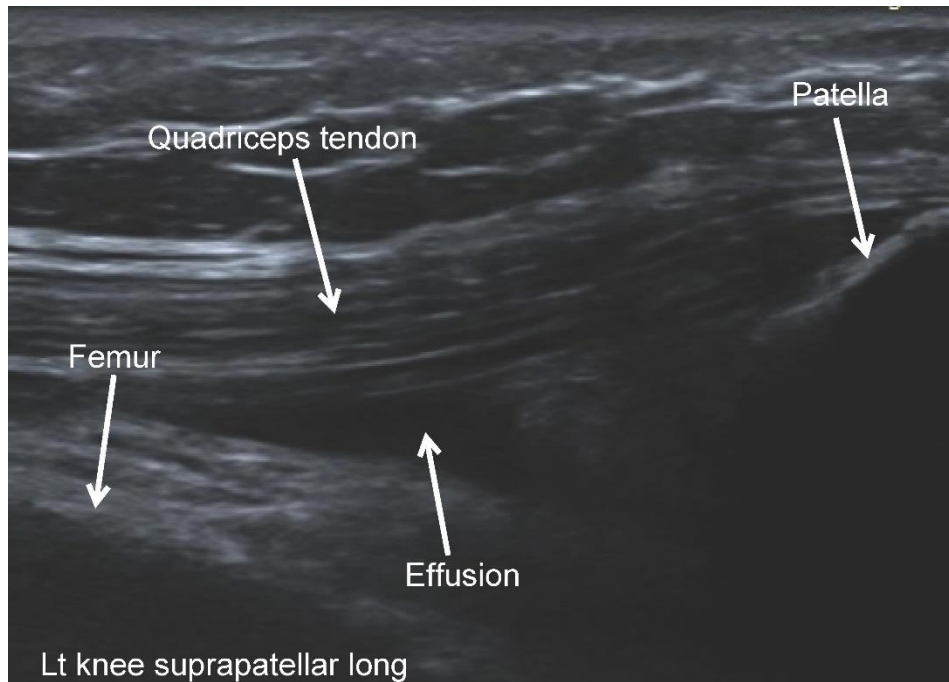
Longitudinal ultrasound image of the suprapatellar bursa in an osteoarthritic knee demonstrating a small effusion and synovial hypertrophy.
